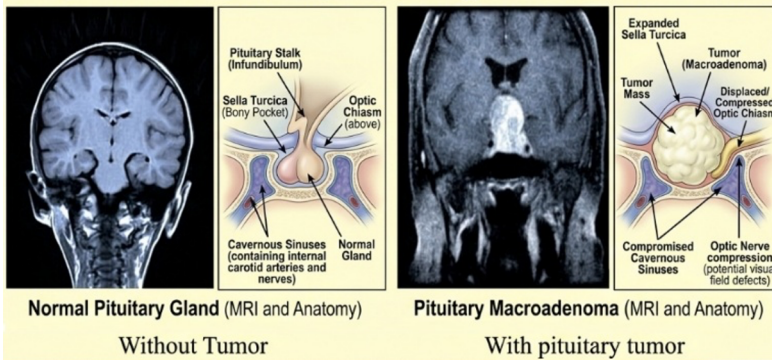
MRI and comparative anatomy of the pituitary gland
